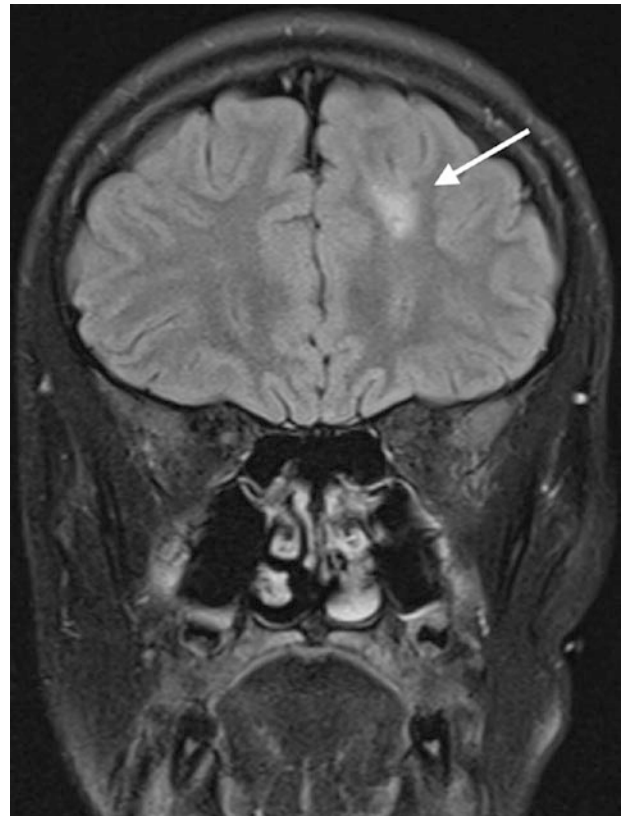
Non-haemorrhagic DAI. Coronal T2 fluid-attenuated inversion recovery (FLAIR) sequence shows abnormal increased signal in the subcortical white matter of the left frontal lobe, consistent with axonal shearing injury
